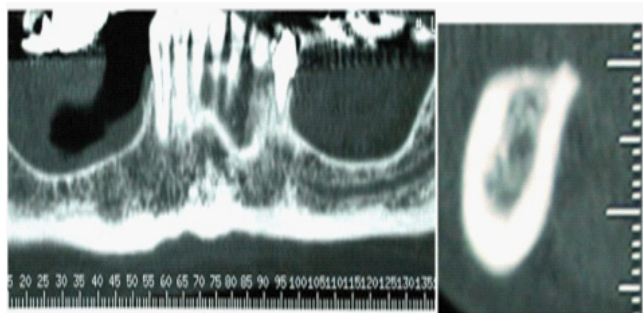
(a,b): CT scan before autograft.
